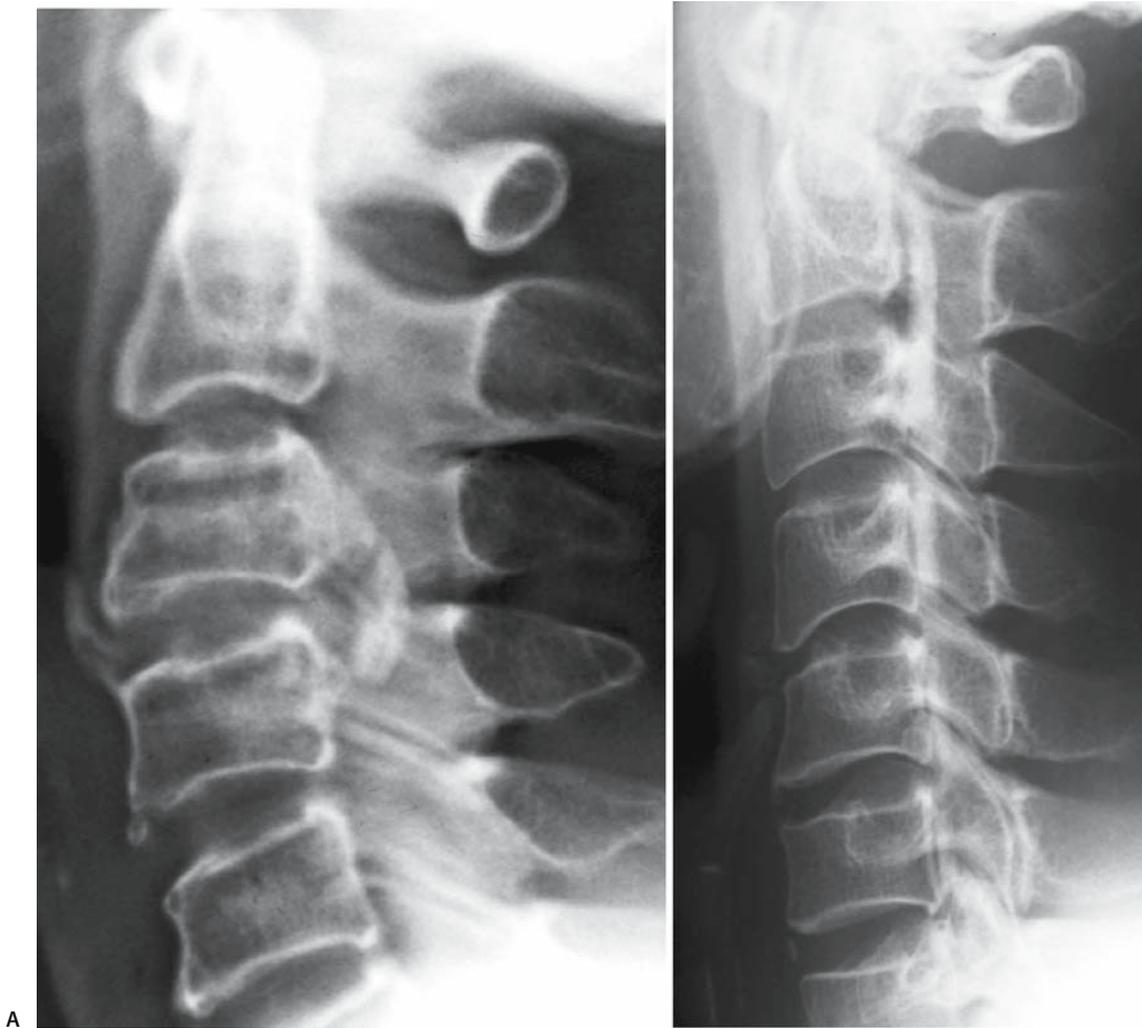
Sagittal shapes of ossification [8,11]. A Tomogram shows a hill-shaped ossified lesion. B Radiograph shows a plateau-shaped ossified lesion
